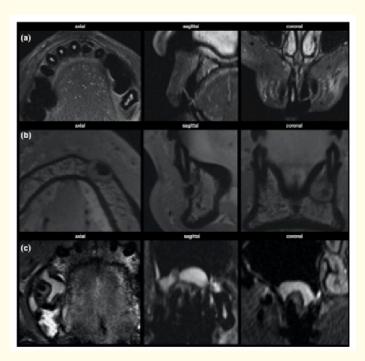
MRI of different indications in endodontics. (a) Horizontal fracture of tooth 21 with loss of MR signal in the necrotic pulp. (b) Apical tumor of tooth 33 with calcified aspect and surrounding osteolysis. (c) Apical granuloma of tooth 16, accompanied by hyperplasia of the basal sinus membrane.
